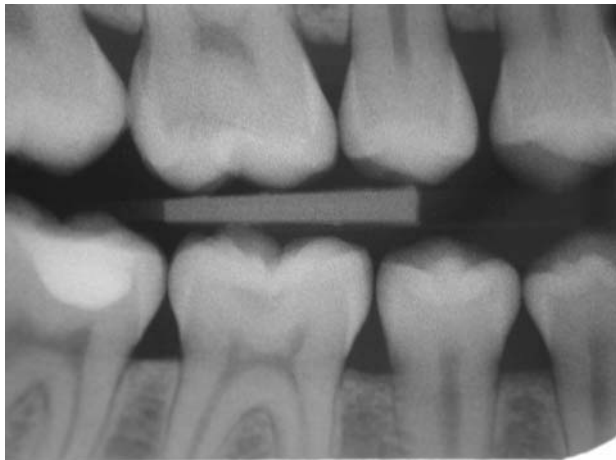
The radiograph of the first molar seen in fig 14 confirmed the clinical detection of caries extending more than 2 mm into dentine occlusally.
